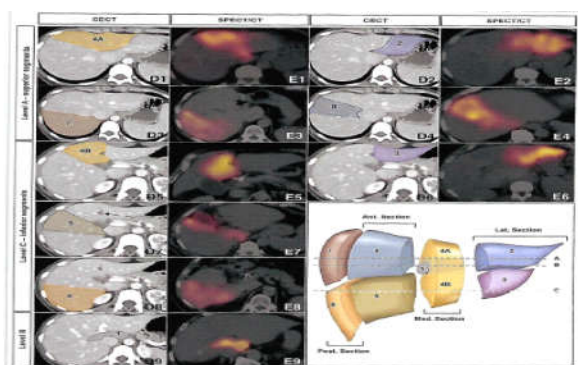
CT Segmental Anatomy of Liver
